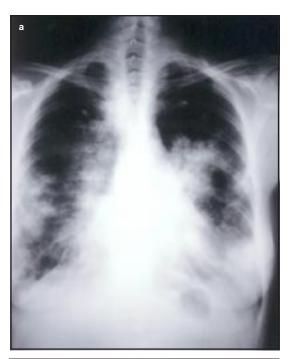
Posteroanterior chest x-ray showing extensive confluent airspace disease in patient 1 upon admission to hospital (a), with interval resolution of pulmonary infiltrates following 1 month of treatment with corticosteroids and cyclophosphamide (b).
